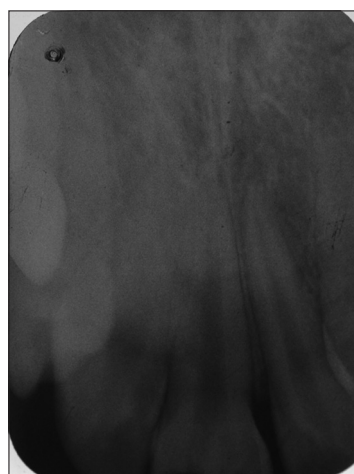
Intraoral periapical radiograph revealing solitary maxillary central incisor with one root and root canal
